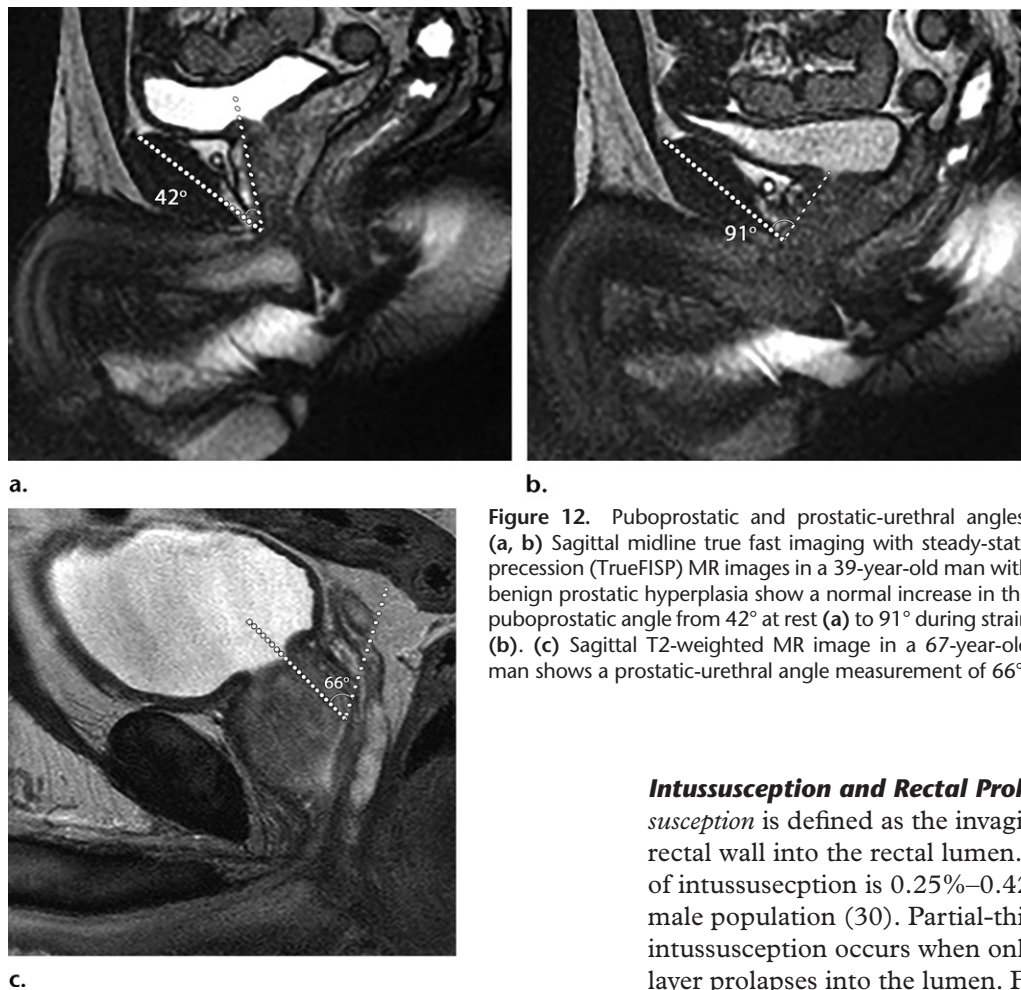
Puboprostatic and prostatic-urethral angles. (a, b) Sagittal midline true fast imaging with steady-state precession (TrueFISP) MR images in a 39-year-old man with benign prostatic hyperplasia show a normal increase in the puboprostatic angle from 42° at rest (a) to 91° during strain (b). (c) Sagittal T2-weighted MR image in a 67-year-old man shows a prostatic-urethral angle measurement of 66°.
